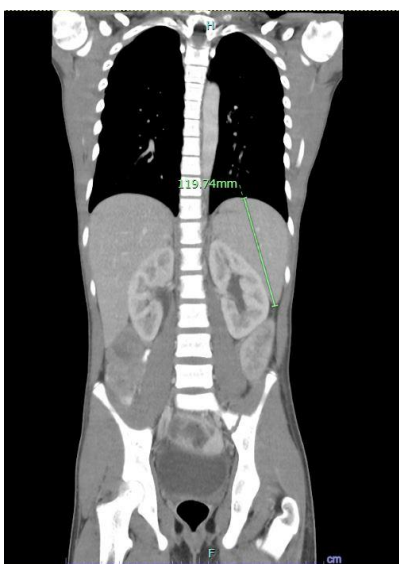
Contrast CT Thorax, Abdomen and Pelvis showing splenomegaly measuring 11.9cm
